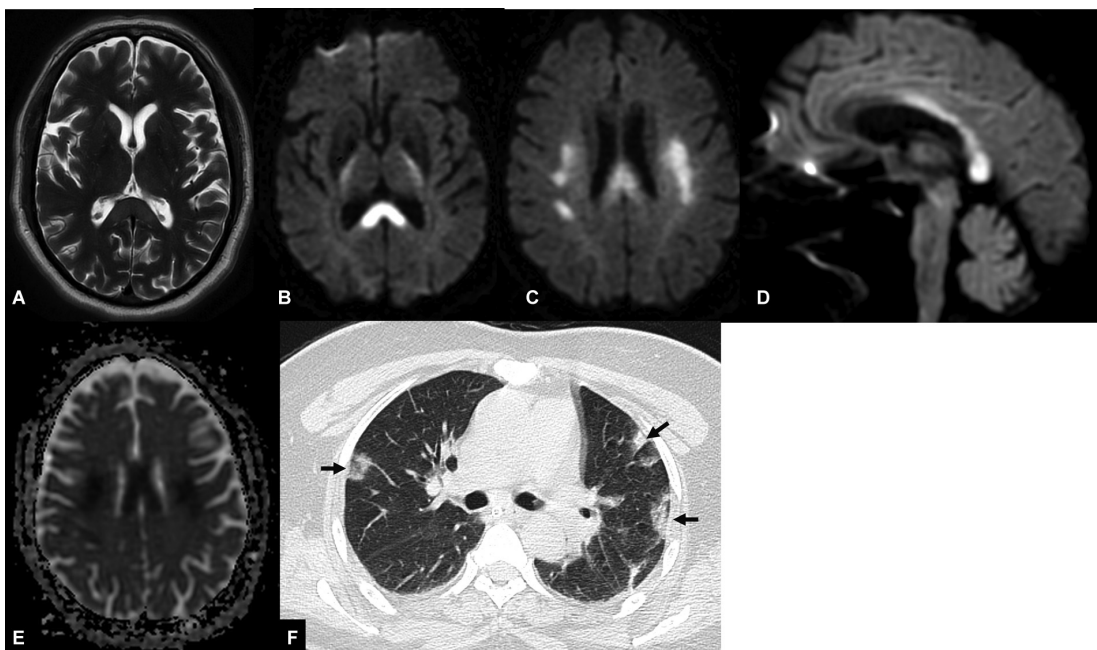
A 65-year-old lady, coronavirus disease 2019 (COVID-19) positive, presented with altered sensorium. Evaluation ruled out any electrolyte disturbance. Magnetic resonance imaging revealed diffusion restriction in the splenium and posterior part of body of corpus callosum, in bilateral corona radiata and posterior limb of internal capsules (A–E). Note the classical peripherally oriented ground glass opacities in lung fields (black arrows) (F). These features are consistent with COVID-19-associated cytotoxic lesions of the corpus callosum.
